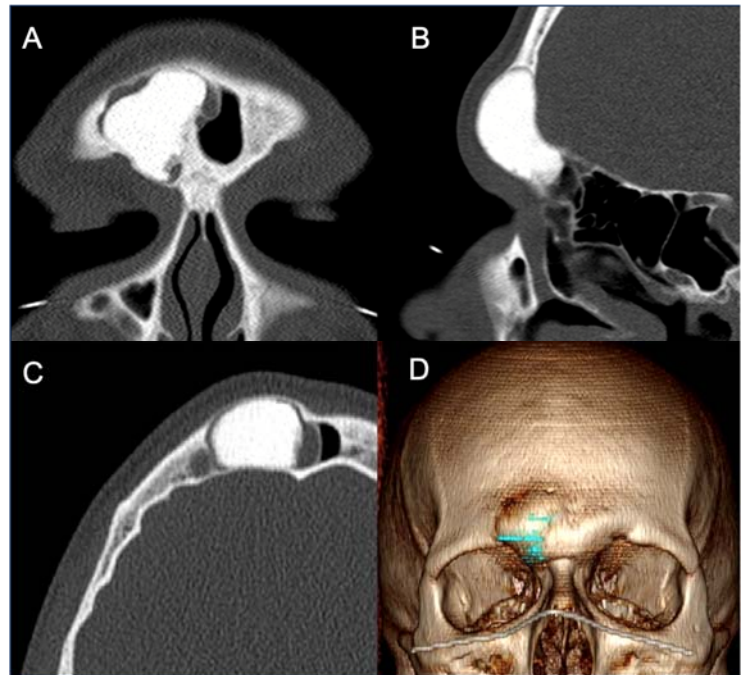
A, B and C) Coronal, sagittal, and axial CT sinus respectively showing right frontal osteoma with associated mucocèle of the right frontal sinus. D) 3D Reconstruction showing right anterior table deformity and mass effect upon the right orbit.
